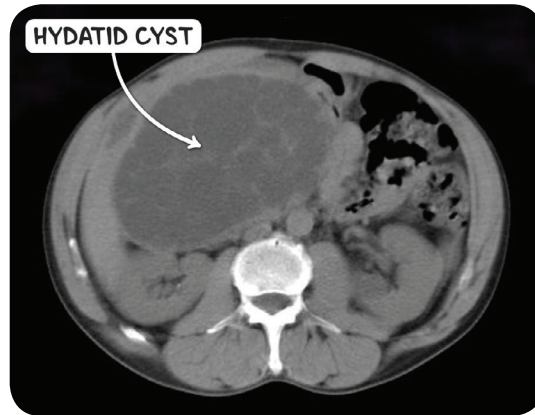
A CT scan of the abdomen in the axial plane demonstrating a large hepatic hydatid cyst. The numerous daughter cysts are faintly visible.
